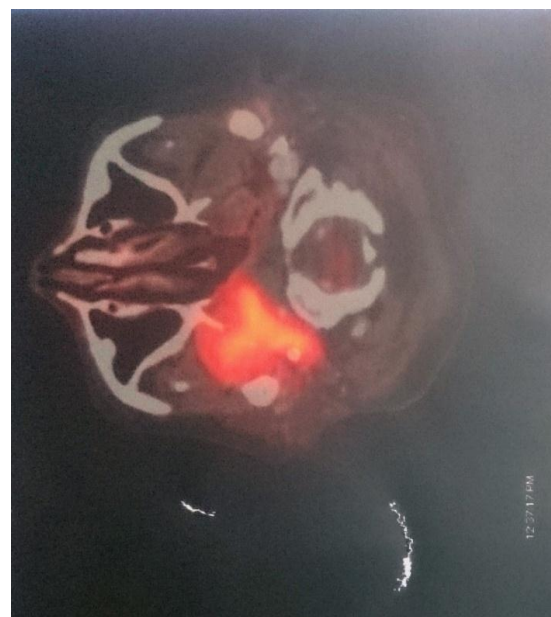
PET CT showing metabolically active areas
